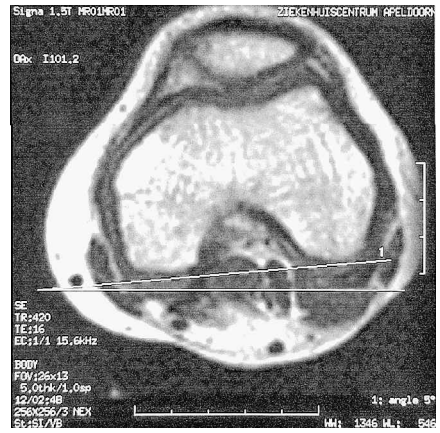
MRI measurement of the beta angle of the left femoral condyles (5°). The true anteversion angle is 15° .
